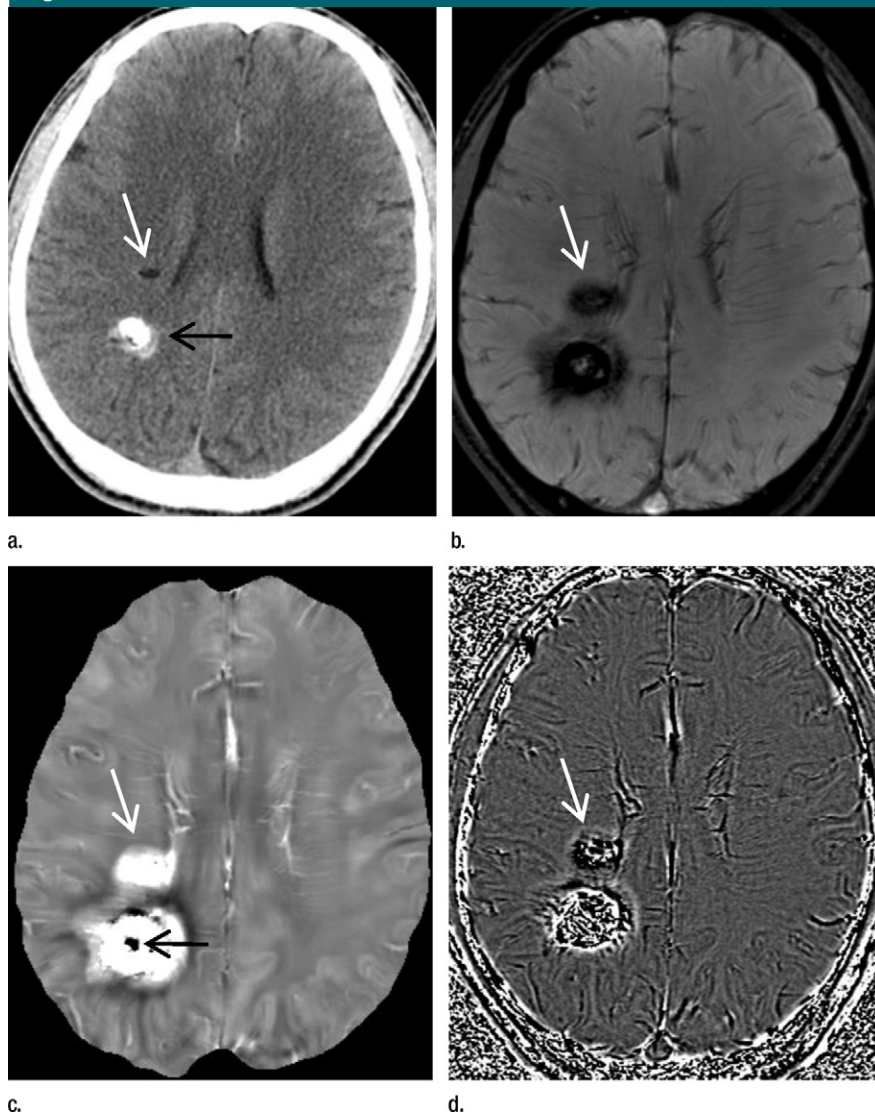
Calcification and hemorrhages (white arrow) in 58-year-old woman with cerebral cavernous angiomas. (a) CT scan shows small hypoattenuating lesion (white arrow) and hyperattenuating calcification (black arrow, CT number >200 HU). (b) T2-weighted MR image shows calcifications and hemorrhages indistinctly with similar appearances (hypointense lesions with iso- and/or hyperintense cores). (c) QSM image shows paramagnetic lesion (white arrow), which corresponds to location of small hypoattenuating lesion on CT scan and was interpreted as chronic hemorrhage, and a large primarily paramagnetic lesion mixed with a diamagnetic center (black arrow). (d) GRE phase image shows both lesions with heterogeneous appearances, making diagnosis difficult. Dense calcified core (black arrow in a and c) was recognized on QSM image by readers 3 and 4.
